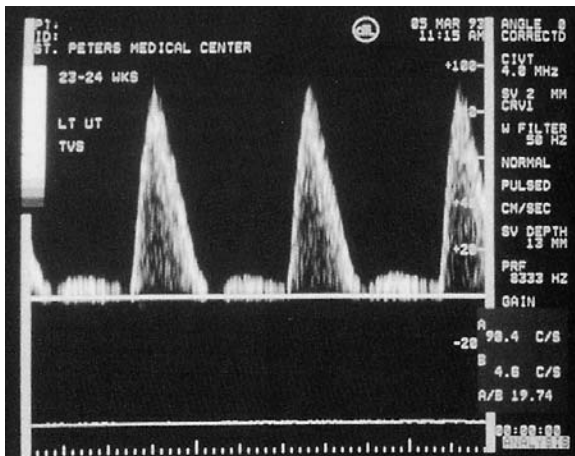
Absent early-diastolic velocities in the uterine artery velocity wave with pulsed Doppler
